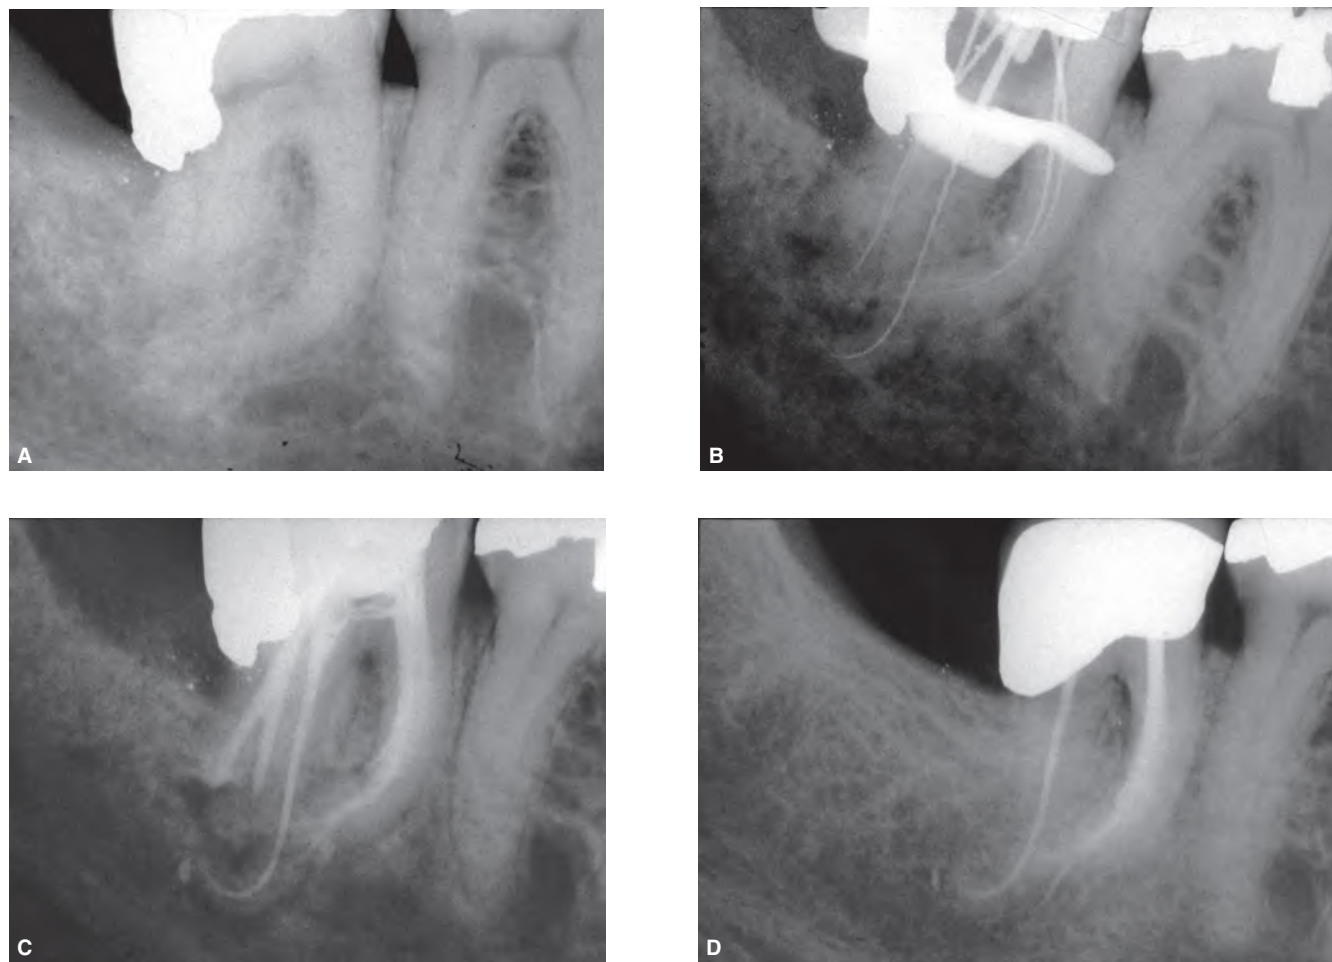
Endodontic treatment in severely curved roots of a mandibular second molar of a 38-year-old male. The patient complained of lingering pain to cold stimuli and the tooth was painful to percussion. A. Preoperative radiograph. B. Length assessment radiograph showing instruments in five separate canals and severe root curvature. C. Immediate postoperative radiograph. D. 11-year recall radiograph. The distobuccal/lingual root complex was resected two years prior because of deepening periodontal pocketing. The patient is asymptomatic and the tooth is stable and restored to function. (Courtesy of Dr. Stephen P. Niemczyk, Broomall, PA.)
